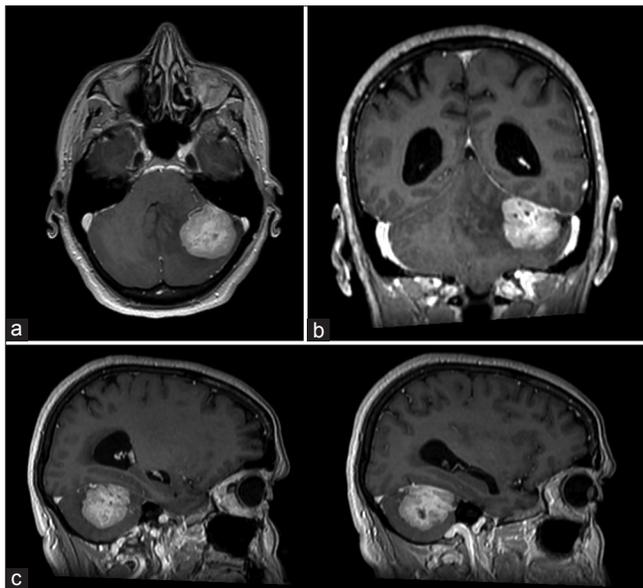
Axial (a), coronal (b), and sagittal (c) T1-weighted magnetic resonance imaging with gadolinium images showing a left cerebellar lesion with a maximum diameter of 43 × 40 mm, with inhomogeneous enhancement, tentorial attachment and “dural tail” sign, highly suggestive for left tentorial meningioma.
